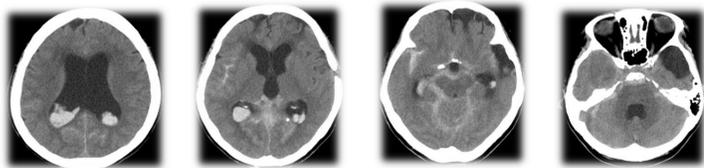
CT axial views of IVH in the lateral ventricles, occipital horns, temporal horns, third ventricles, and fourth ventricles
